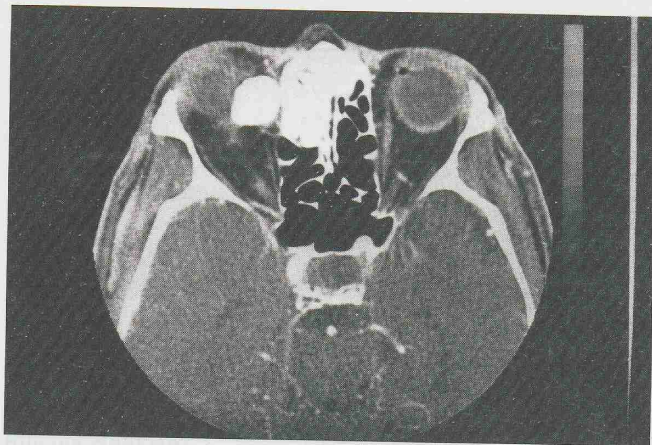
CT scan showing giant frontal sinus osteoma.
